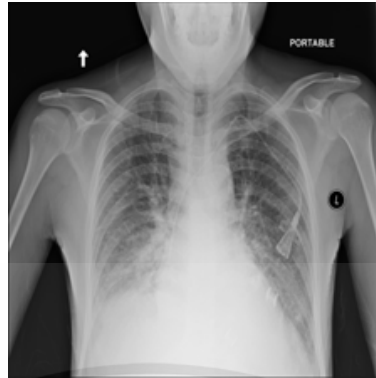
Example of Edema chest X-Ray image (Wang, Yifan Peng, Le Lu, Zhiyong Lu, & Ronald M. Summers, 2018)
